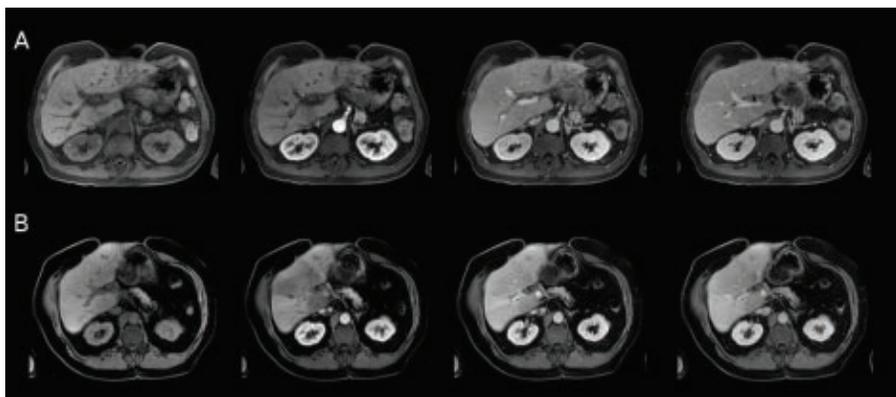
• Comparison of Avanto (A; TE: 1.7ms; TR: 3.7ms; flip angle: 10°; slice thickness: 3.5mm; slices: 64; acquisition time: 16sec) and Avanto-Fit (B; TE: 2.4ms; TR: 6.6ms; flip angle: 10°; slice thickness: 3mm; number of slices: 64; acquisition time: 13.6sec) body examination with equivalent T1-weighted volumetric interpolated breathhold examination (VIBE).
